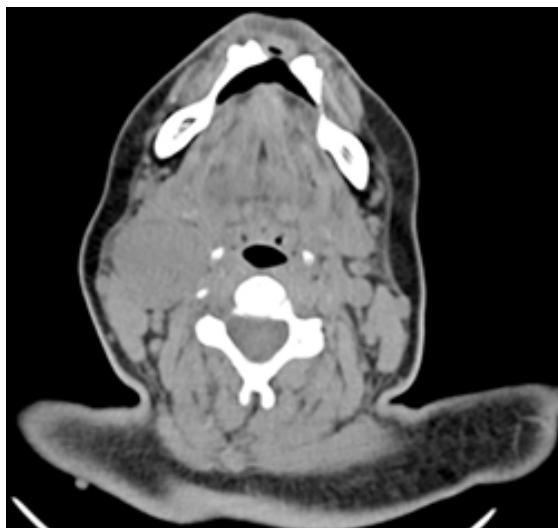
Axial soft tissue window, 2 mm slice thickness, non-enhanced CT.
